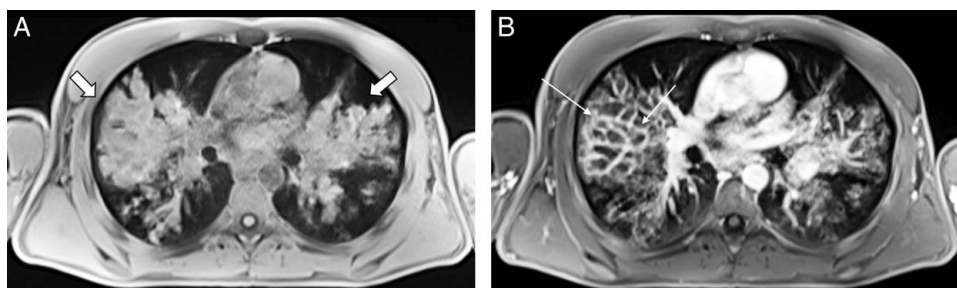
A 20-year-old male with cystic fibrosis. A, Axial nonenhanced T1-weighted fat suppressed MR image shows tubular regions of hyperintense signal (wide arrows) corresponding to bronchiectasis and mucous plugging in bilateral upper lobes. B, Axial enhanced T1-weighted fat suppressed MR image shows bronchial wall hyperenhancement and thickening (thin arrows) which are better delineated than on nonenhanced images.
